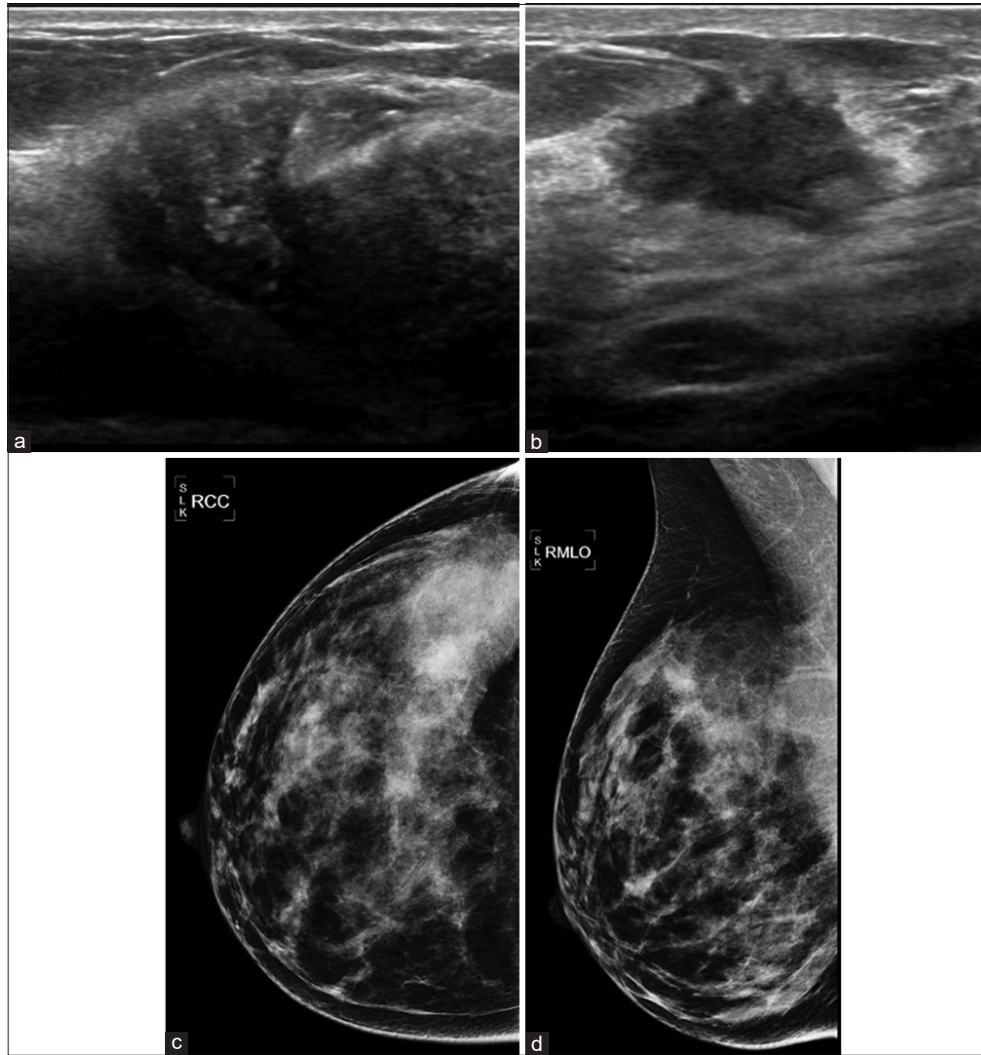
A 26-year-old woman who was 25 weeks pregnant presented with a palpable right breast mass. Initial evaluation was performed with a right breast ultrasound. Longitudinal (a) and transverse (b) ultrasound evaluation of the palpable area in the right breast at the 11 o'clock position, 4 cm from the nipple, demonstrates an irregular hypoechoic $1.4 \times 1.4 \times 1.7$ cm mass (arrow) with associated calcifications. (c) Craniocaudal and (d) mediolateral oblique views of the right breast demonstrated lactation changes. There is an irregular mass with obscured margins at the 11–12 o'clock position, 6 cm from the nipple (arrow). Ultrasound-guided core needle biopsy revealed invasive ductal carcinoma and ductal carcinoma *in situ*.
